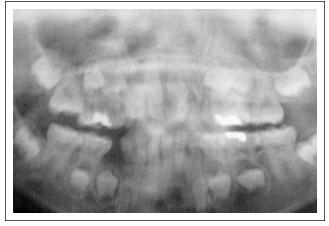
Panoramic radiograph showing generalized delayed dental development and malformation of roots of 16, 26 and 46.
